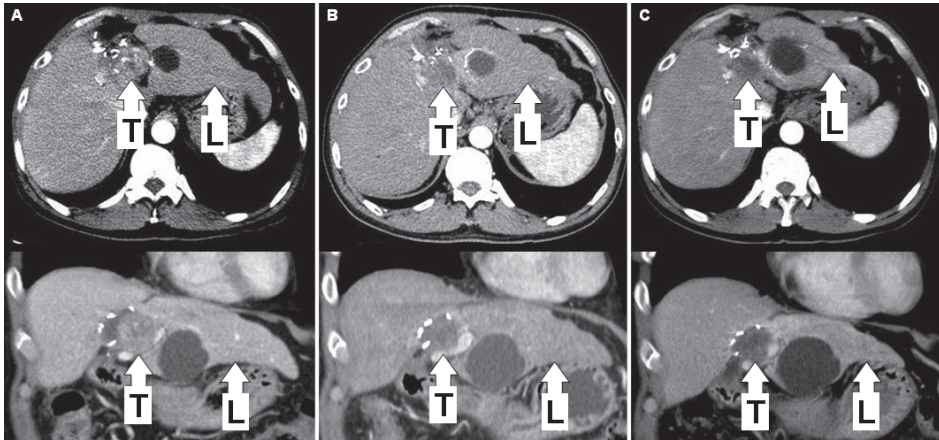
Patient 2: Baseline triphasic CT liver shows the recurrent HCC at the segment IV resection margin (A). Follow-up triphasic CT liver at three (B) and six (C) months post-radioembolization showed good tumor ('T'; 133 Gy) response with progressive atrophy of the left lobe ('L'; 93 Gy), in keeping with left radioembolization lobectomy intent. Right lobe volume (27 Gy) remained stable.
